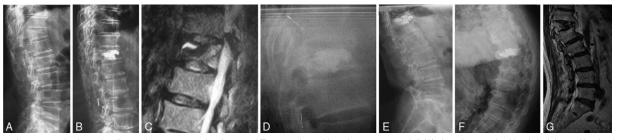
A preoperative lateral radiograph: a compression fractured T12 vertebra with an intraosseous cleft (A). Anterior vertebral body height and kyphotic angle were notably corrected after kyphplasty (B). Two weeks later, an unfilling intraosseous cleft containing fluid with high-signal (C). One month later, the injected PMMA cement was condensed and reduced in size with slight anterior height loss (D). Ten months later, 1 significant compression fracture of T12 vertebral body (E). Sixteen months follow-up radiograph: bony union of T12 vertebral body (F). MRI: no bone marrow edema with high-signal at T2 image (G). MRI = magnetic resonance image, PMMA = polymethylmethacrylate.
